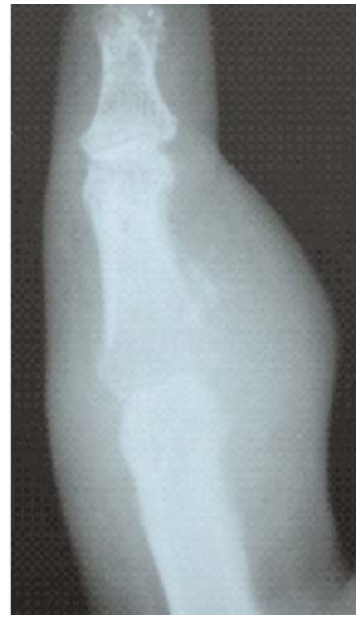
Radiograph of left ring finger.
